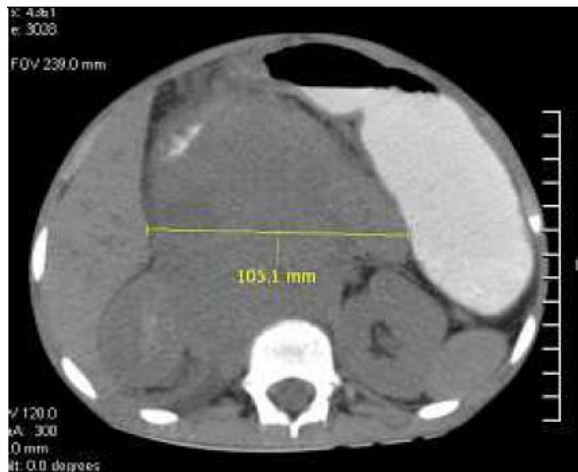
Hepatoblastoma. CT image show large mass in liver
